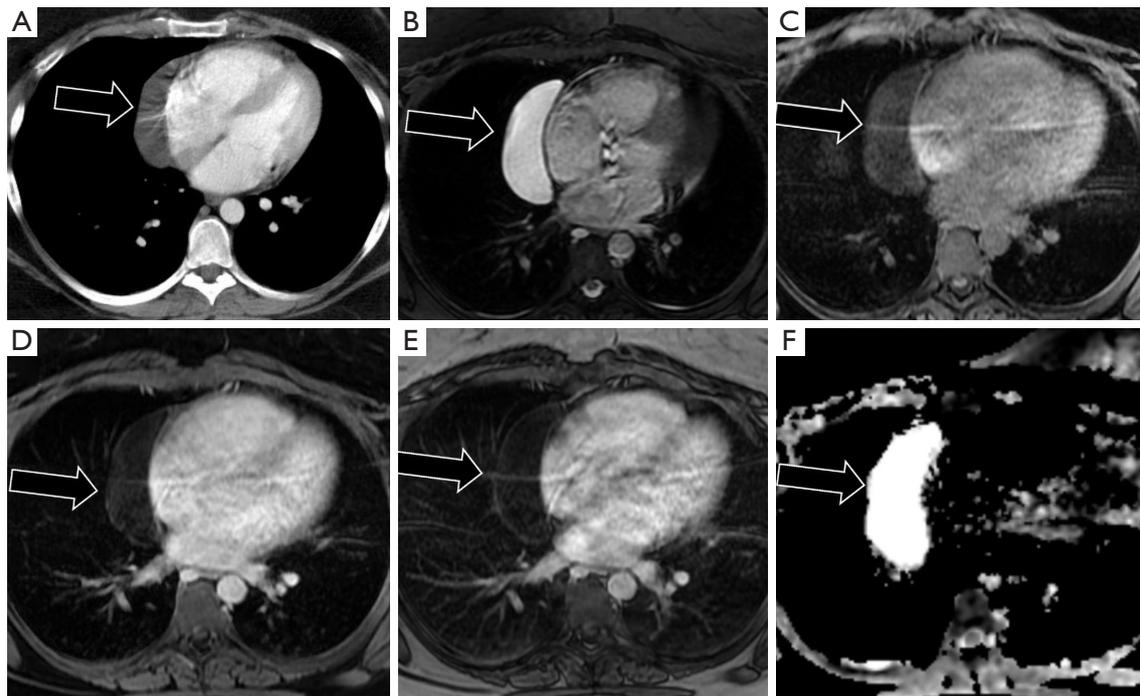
26-year-old female with pericardial cyst. CT imaging (black arrow) demonstrates a fluid density lesion along the right cardiac border (A), corresponding to T2W hyperintensity (B) and T1W hypointensity (C). The lesion does not demonstrate gadolinium enhancement (D), confirmed on delayed acquisitions (E). ADC maps demonstrate increased diffusivity (F). The location and imaging findings are confirmatory for pericardial cyst. CT, computed tomography; ADC, apparent diffusion coefficient.
